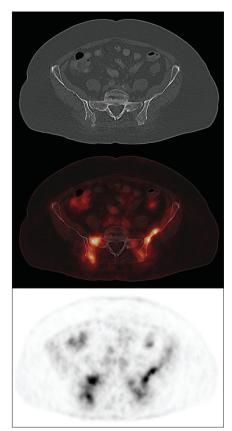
FDG PET-CT transaxial images showing increased FDG uptake in the bilateral iliac bones and sacrum with prominent hypermetabolic activity extending beyond the borders of the bone in the musculature and subcutaneous tissues
